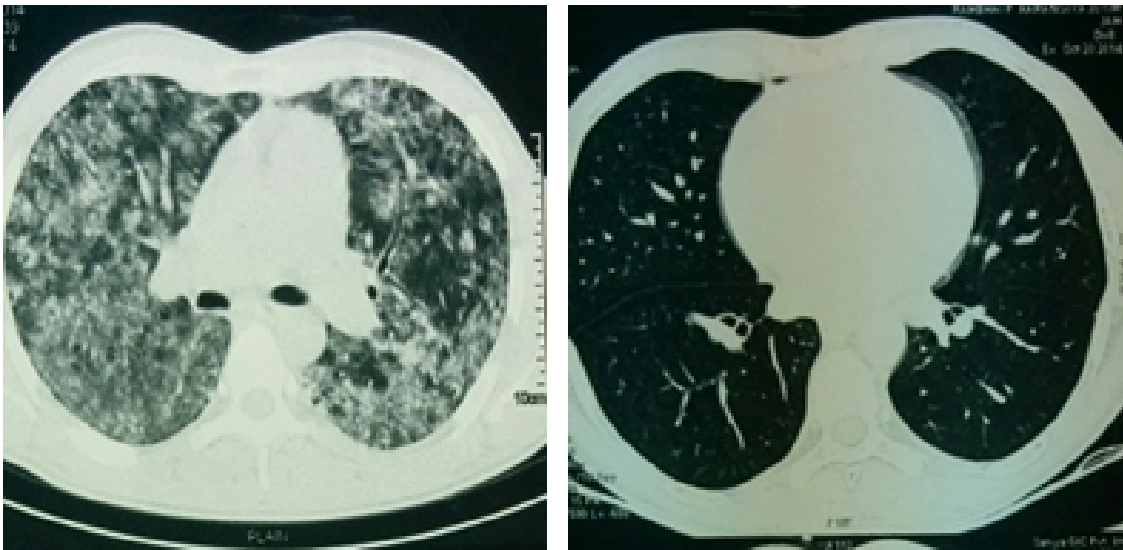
CT Images – Before and after treatment
